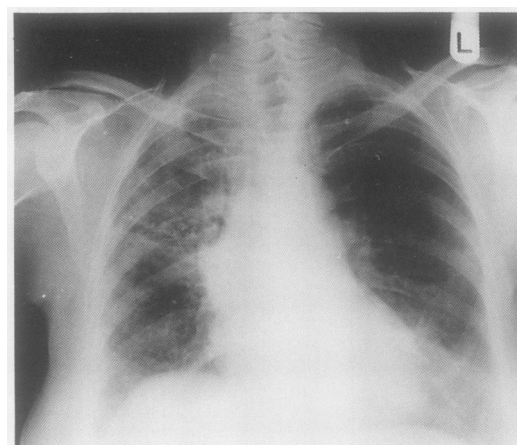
Chest radiograph showing areas of ill defined consolidation particularly affecting the right upper and left mid zones with reduction in the volume of the right lung.
